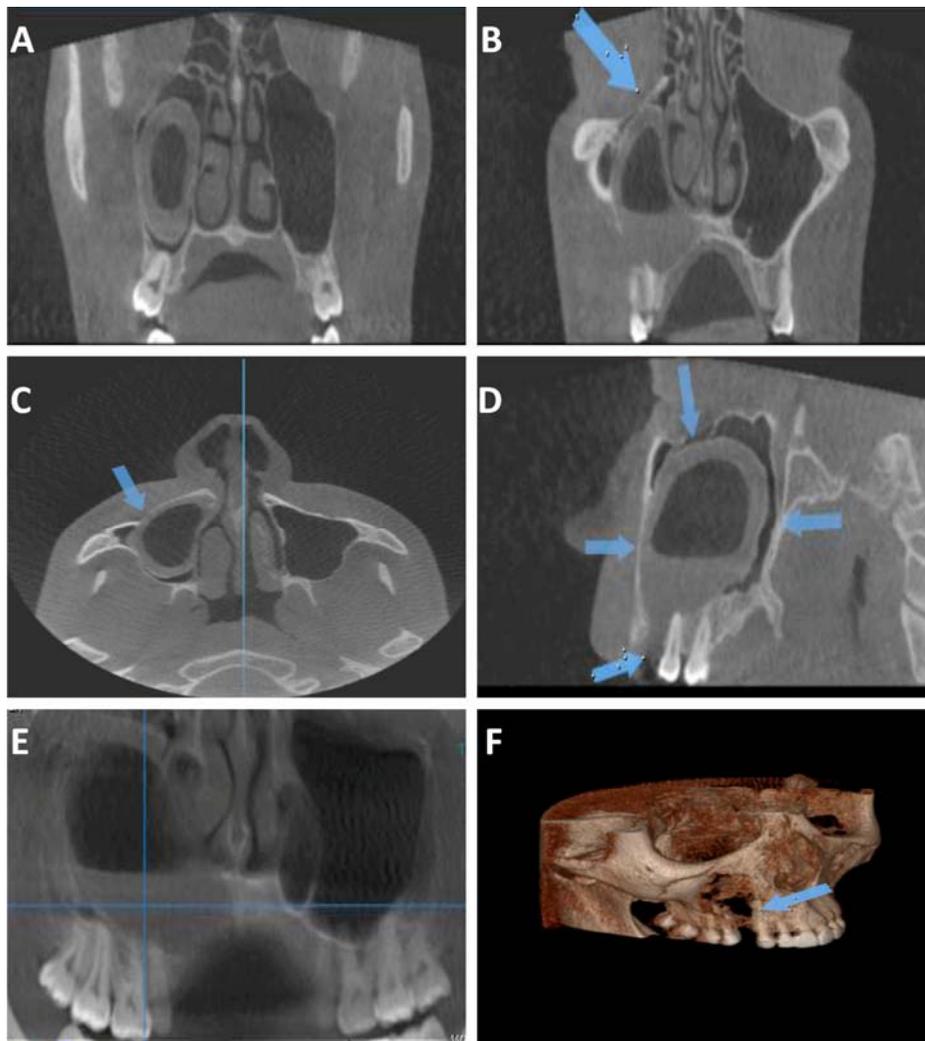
Cone-beam computed tomography (CBCT) scans 6 months following decompression. A) The coronal view clearly shows the reduced size and thickening of the cystic lesion; B) The coronal view shows decompression of the infraorbital canal and the orbit; C) The axial view shows the thickened cystic sheath and its separation from the maxillary sinus walls; D) The sagittal view demonstrates cystic reduction and canal decompression; E) Panoramic thin-slice image shows the maxillary sinus; F) The 3D image of the affected site shows the reduced bony defect.
